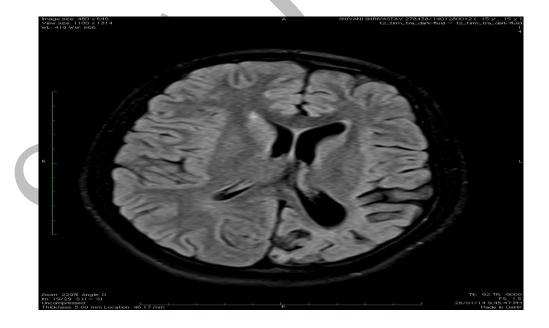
Brain MRI axial FLAIR image show left cerebral atrophy and ipsilateral dilatation of the ventricles
